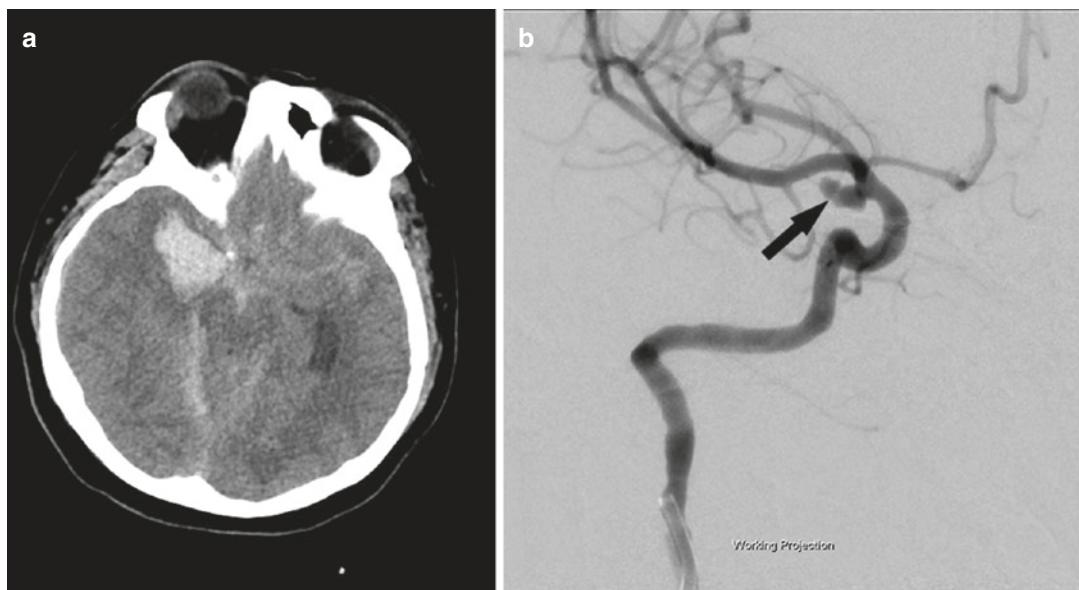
(a) Noncontrast CT scan of the head showing a subarachnoid hemorrhage and right temporal hematoma. (b) An angiogram shows an aneurysm (*black arrow*) of the posterior communicating artery
